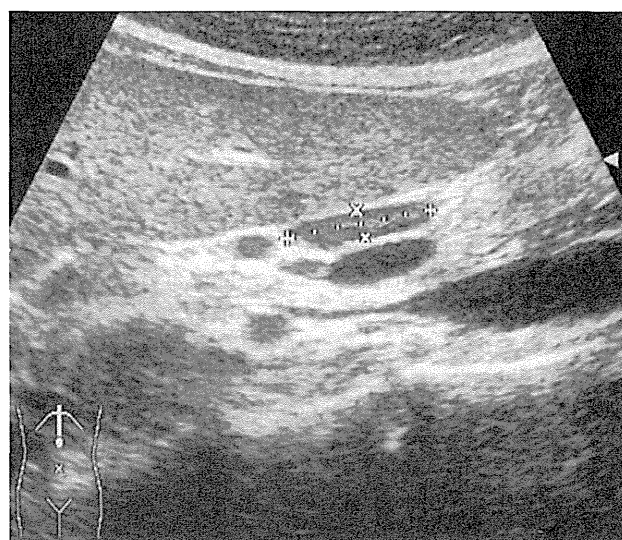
Representative ultrasound image of enlarged perihepatic lymph node (LN) in a patient with chronic hepatitis C
